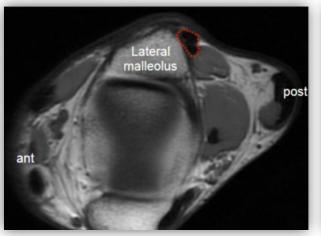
Axial proton-density weighted MR image demonstrates the peroneal tendon sheath (red dashed outline) in the retro-malleolar zone.
